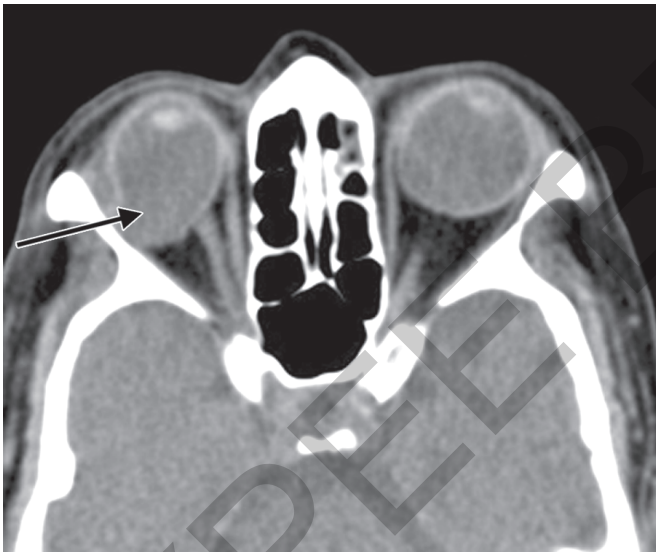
Axial CT orbit of a myopic patient showing a focal bulge temporal to optic disc with scleral thinning—posterior staphyloma (arrow)
